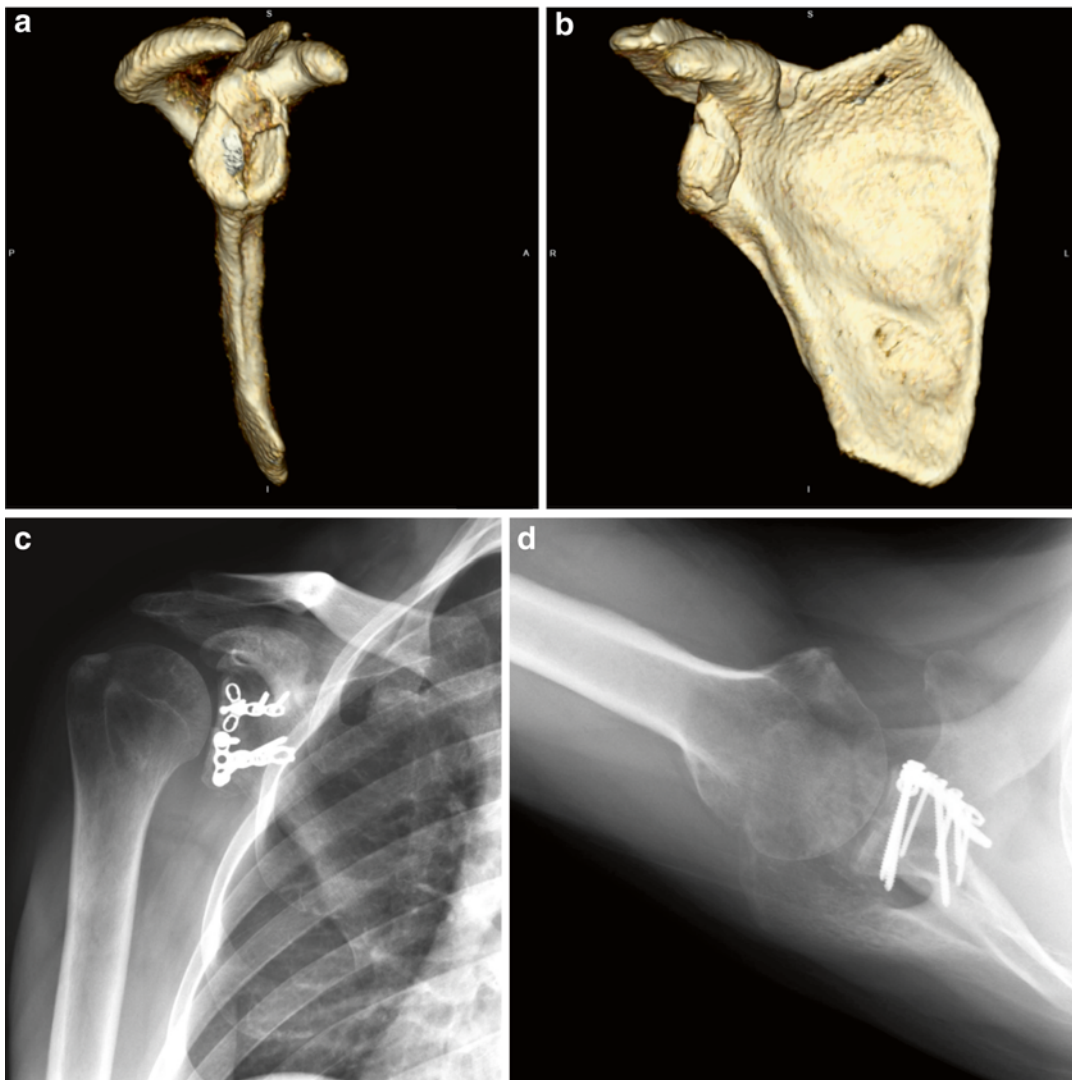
The 3D reconstructed CT image oriented in the anteroposterior (a) and the scapula Y (b) views for a patient presenting with a displaced anterior scapular glenoid fracture requiring operative fixation. Mini fragment
